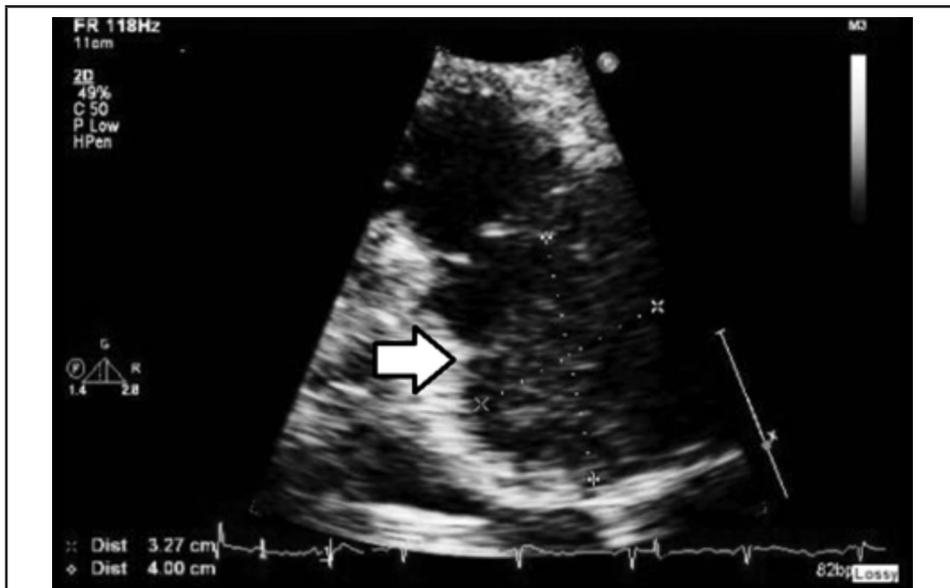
Transthoracic echocardiographic image of right atrium shows 4.0 x 3.27 cm mass (arrow) nearly obliterating the right atrial cavity.
